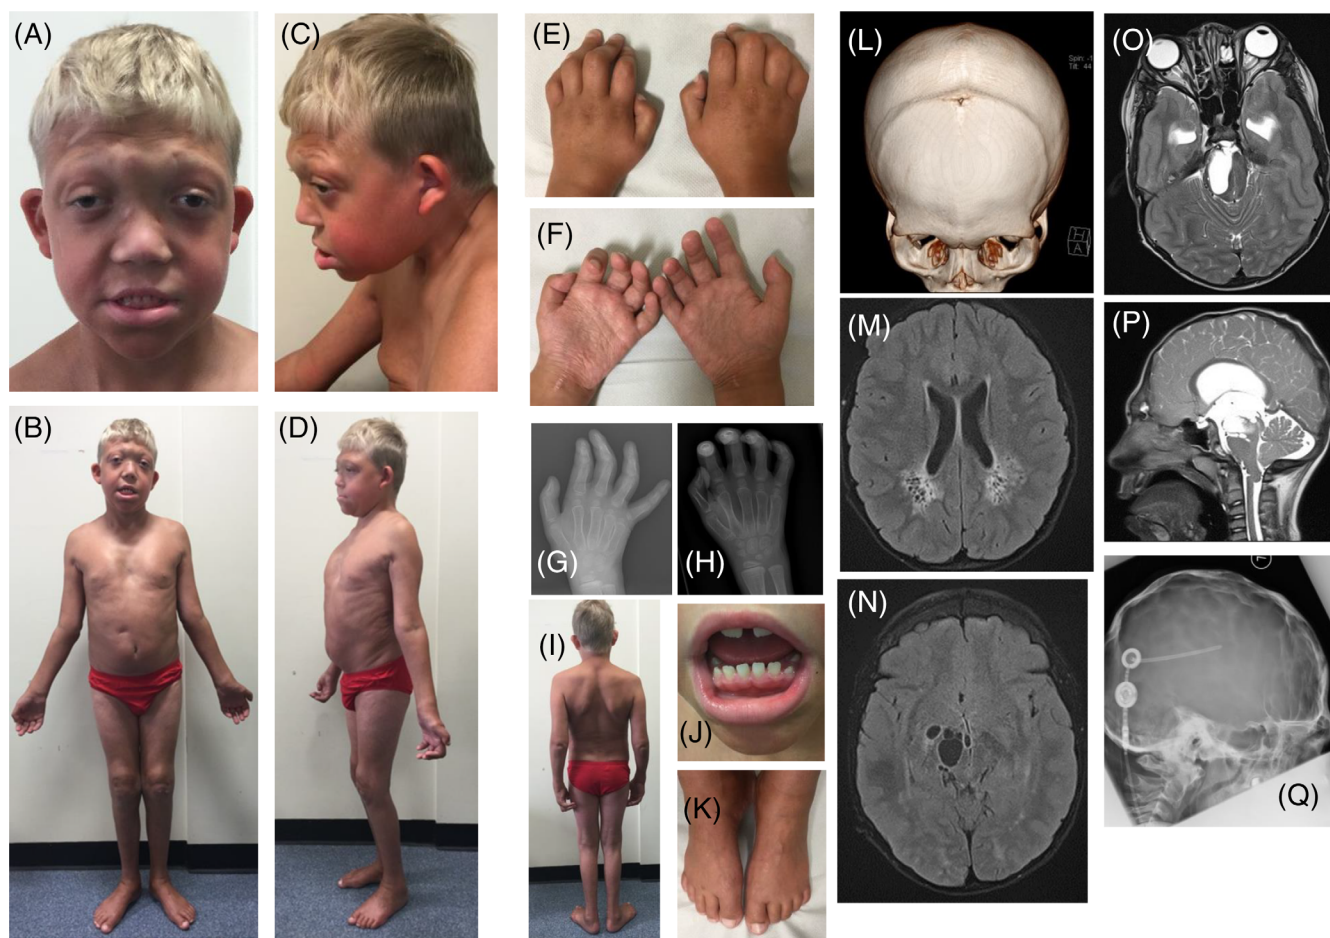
Clinical features and imaging of patient 2. Features of the face and cranium, A-D, brachycephaly, sloping forehead, prominent supraorbital ridge, wide spaced eyes, proptosis, downslanting palpebral fissures, wide nasal bridge, wide nasal base, wide nasal tip, malar flattening, midface retrusion, smooth philtrum, thin vermilion of the upper lip, everted vermilion of the lower lip, protruding ears with forward facing and uplifted earlobes, widely spaced teeth and class III malocclusion resulting from midface retrusion (J). Tanned appearance with thin hyperelastic skin and wrinkled palms, B,D,F. Tall body habitus with pectus excavatum and reduced extension of the elbows, B,D. Progressive flexion contractures of the fingers and short wide thumbs, E,F. Broad feet (K). Hand and foot x-rays age three, G, and five, H: Widening of metacarpals and phalanges with a degree of carpal crowding and some widening of the metatarsals and phalanges; progression of contractures. L: CT head age 18 months with almost complete fusion of the sagittal, coronal and metopic sutures. M and N: MRI head age three showing generalised parenchymal volume loss, bilateral posterior periventricular T2 high and flair high signal with focal areas of low signal in keeping with cystic changes, right cerebral peduncle T2 high signal and Wallerian degeneration with severe cystic gliosis, and small foci of flair hyperintensity in the bilateral centrum ovale suggesting acute ischaemic foci. O and P: MRI head age five showing foci in the right midbrain occluding the third ventricle and cerebral aqueduct causing increase in size of the bilateral lateral ventricles and third ventricle, mild mass-effect with midline shift, inferior descent of the brainstem and cerebellar tonsils and possible compression of the optic nerve/chiasm. Q: CT head age five showing copper beaten skull related to chronic raised intracranial pressure [Colour figure can be viewed at wileyonlinelibrary.com]
